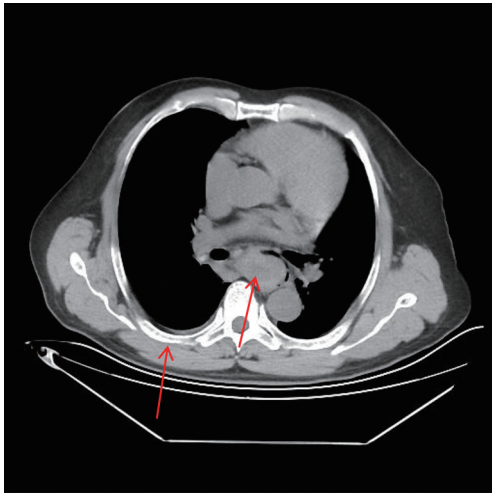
Lung CT showed soft tissue-like density in the esophagus (the arrow on the left indicates a small amount of pleural effusion; the arrow in the middle indicates soft tissue like-density in the esophagus). CT, computed tomography.
